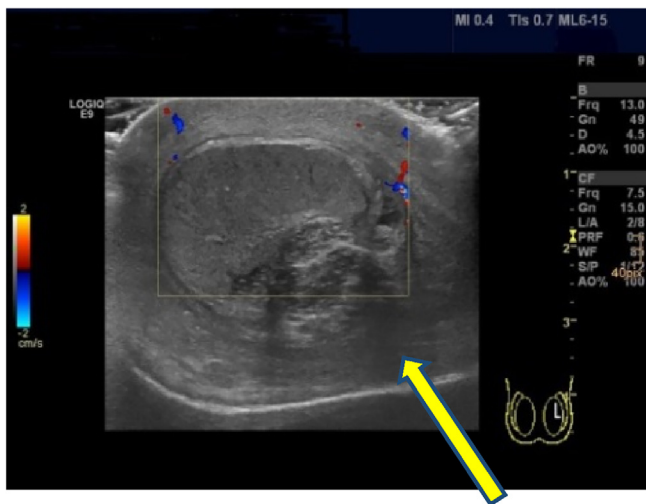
The sonographic aspect of the left testicle without central perfusion and with an altered structure (GE Logiq E9 ultrasound equipment).
